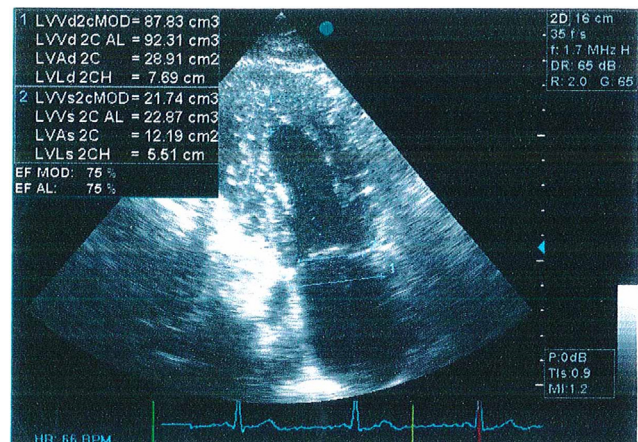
Assessment of LV systolic function by 2D Simpson on apical 2 chamber view.
